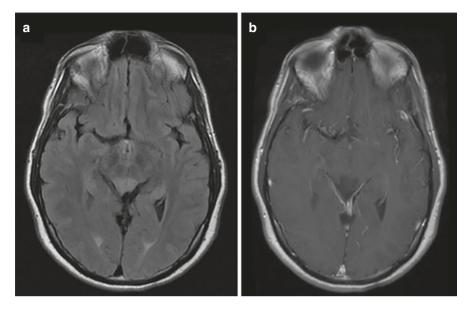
Brainstem involvement in a patient with biopsy-proven Whipple's disease. (a) Tectal hyperintensity on FLAIR images. (b) Lack of enhancement on post-contrast T1-weighted images
